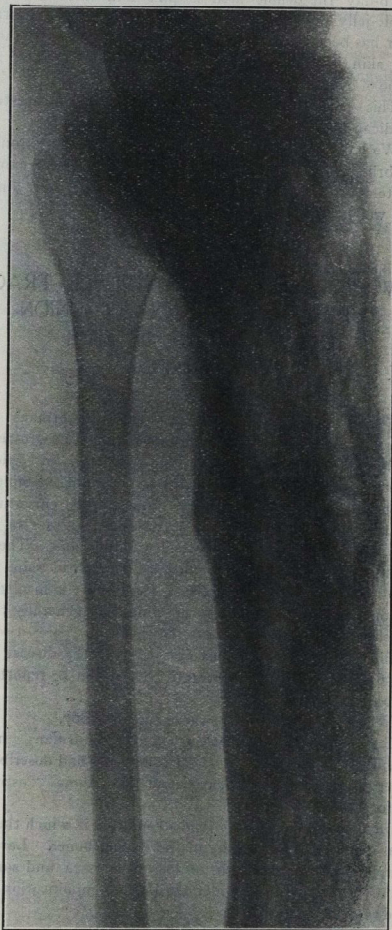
G. W.—. X-RAY PHOTOGRAPH ON ADMISSION.
